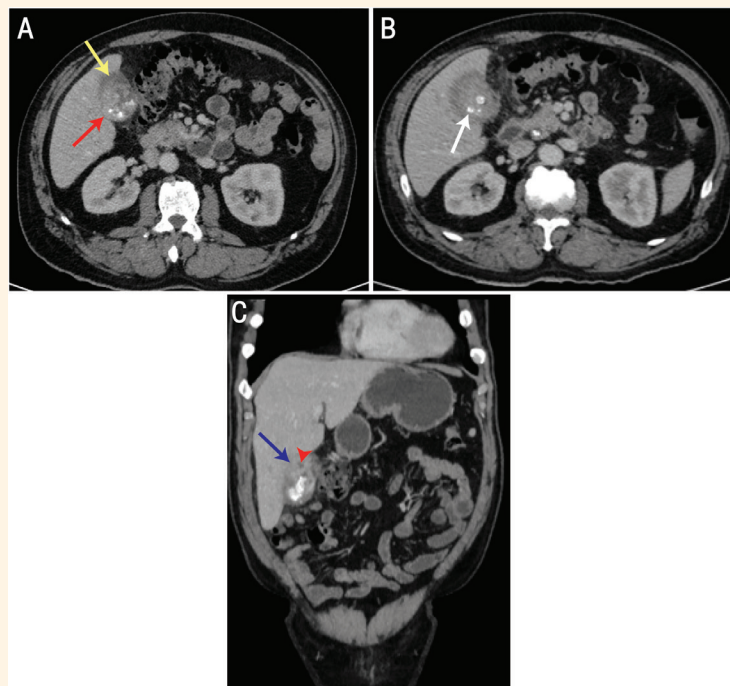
Contrast enhanced computed tomography scans of the abdomen of a 61-year-old male patient in axial and coronal views demonstrating: (A) Irregular diffuse gallbladder mural thickening (red arrow) and pericholecystic fluid collection (yellow arrow), (B) Multiple hyperdense calculi (white arrow) and (C) A few hypoattenuating mural nodules (arrowhead) and poor fat planes to the adjacent liver parenchyma (blue arrow).
